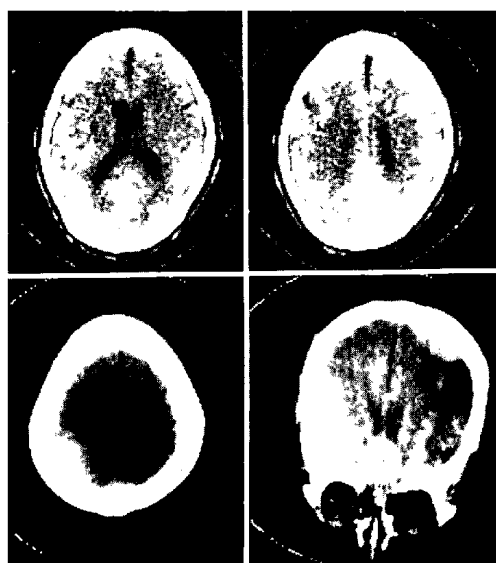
Epidural hematoma. 66-year-old male. Transverse CT was performed one day and coronal CT was done 2 days after trauma. An epidural hematoma of high convexity cannot be identified with reasonable accuracy by the transverse section scan alone. A characteristic biconvex appearance is clearly visible only by the use of coronal section scan.
